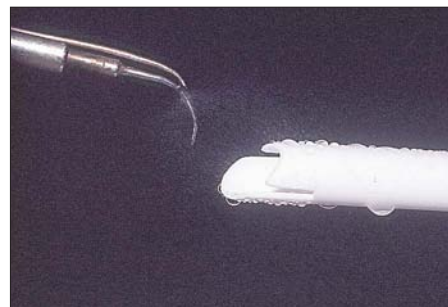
The use of a 6 mm to 8 mm diameter high volume evacuator with an ultrasonic scaler will eliminate almost the entire aerosol. The use of an HVE by an assistant has been shown to reduce airborne contamination by more than 90 percent.
